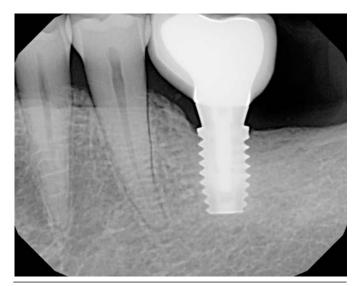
Periapical radiograph of the PFGIC abutment-implant connection.
